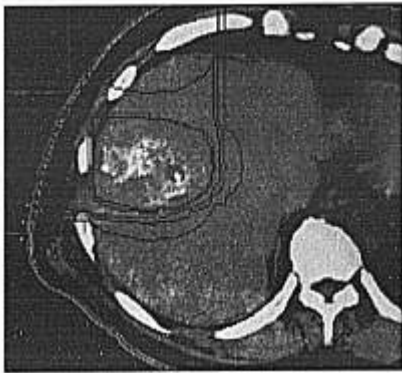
Noncontrast CT scan performed before proton therapy for hepatocellular carcinoma (HCC). This section is immediately caudad to the lower edge of the HCC. The remnant of oily contrast media is hyperdense following embolotherapy. Isodose distributions are superimposed. Proton beams were delivered through anterior and right lateral portals. The innermost contour represents the maximum dose area (100%). The outmost black lines represent 10% isodose.
